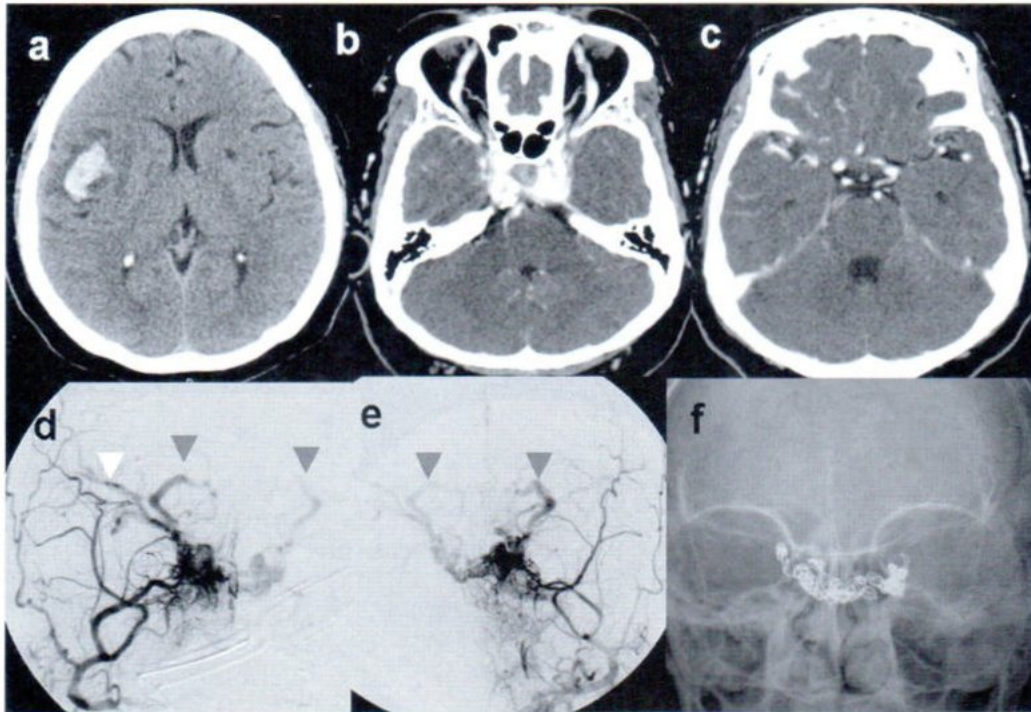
Noncontrast brain CT (a) showed an acute ICH at the right frontal lobe periinsular region and an old lacune at the left lentiform nucleus. Contrast enhanced CT showed (b,c) showed enlargement of both cavernous sinuses, SOVs, and too much enhanced vessels at the right frontal and temporal lobes (red arrows). Right external carotid (d) and left external carotid (e) angiograms AP view showed DAVF at both cavernous sinuses with venous reflux into the SOVs (green arrows), right middle cerebral vein (yellow arrow), and also the intercavernous sinus. Skull film AP view (f) showed the position of the transvenous embolized coils.
